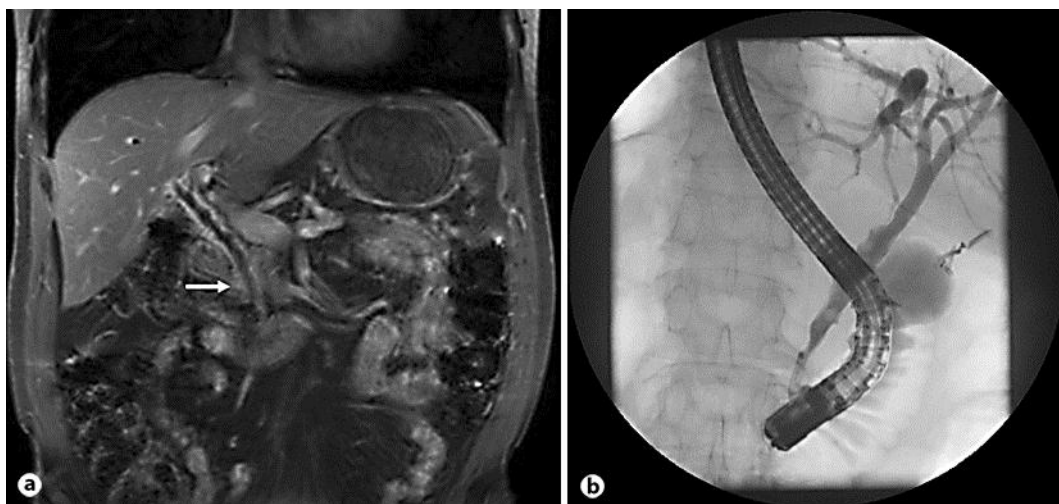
a Following 3 months of immunosuppressive therapy, coronal contrast-enhanced T1-weighted image displayed normal pancreas morphology without malignancy and regressive cholestasis with thin DHC (white arrow). b Follow-up ERCP demonstrated a completely regressive development of the diverse stenoses of the DHC and the main right and left bile ducts.
